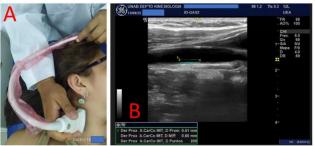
Representative image of the  $cIMT_{av}$  and  $cIMT_{max}$  measured by the automatic option with B-mode of an ultrasound machine.
